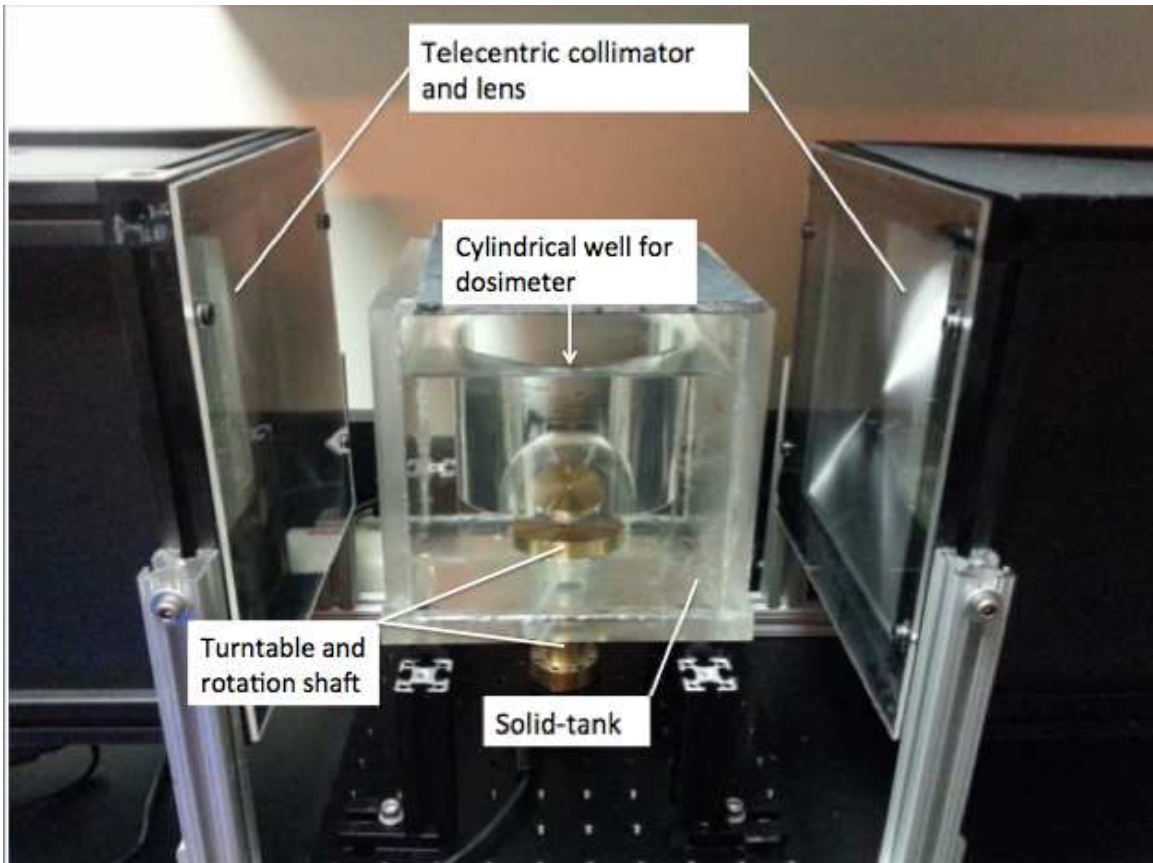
Duke Fresnel-based optical-CT scanner (DFOS), consisting of a solid
